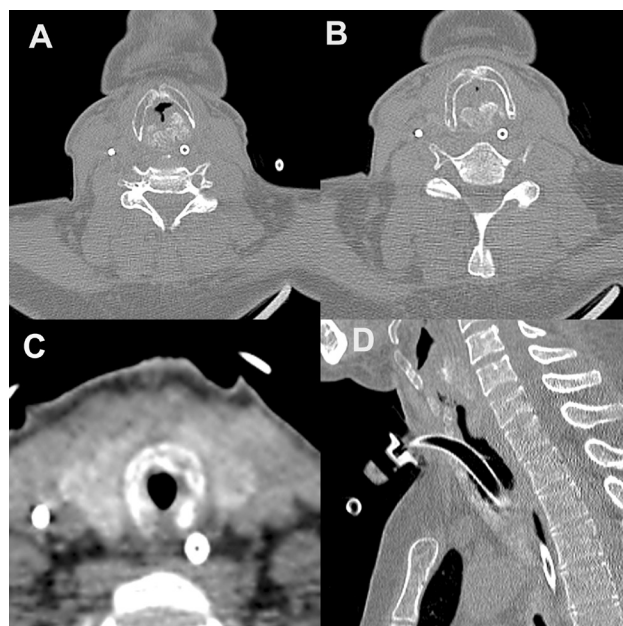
(A,B,C) axial CT images of the neck demonstrating extensive thickening and calcification of the thyroid and cricoid cartilages, with marked subglottic stenosis. (D) a sagittal reformatted CT image of the upper chest showing calcification along the anterior tracheal wall in addition to the stenosis caused by laryngeal cartilage thickening. The posterior tracheal wall is preserved, as seen in figures 1C and D.
